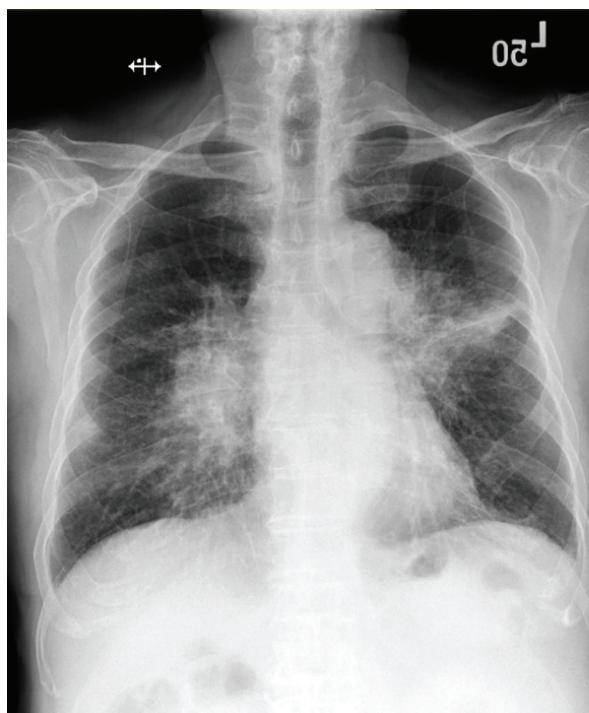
The first chest radiograph in our hospital showed patchy consolidations with a central distribution in the bilateral hilar area.
